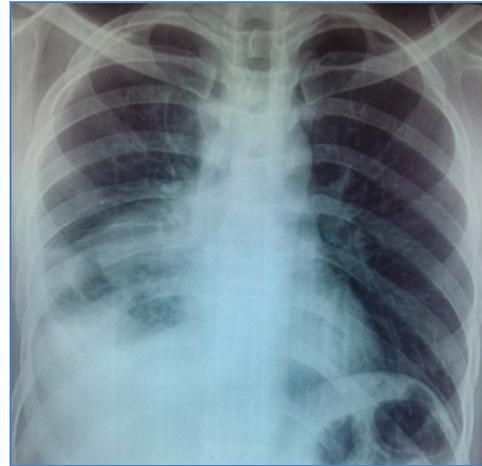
Chest x-ray PA- 2 (post-aspiration)
